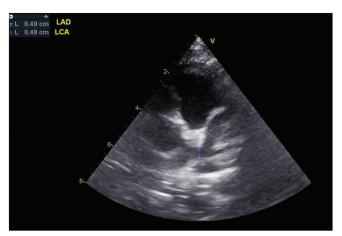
Parasternal short axis view is showing the diffuse dilatation of left main and anterior descending coronary arteries. The internal diameter is measured as 0.48–0.49 cm. LAD: left anterior descending artery, LCA: left coronary artery
